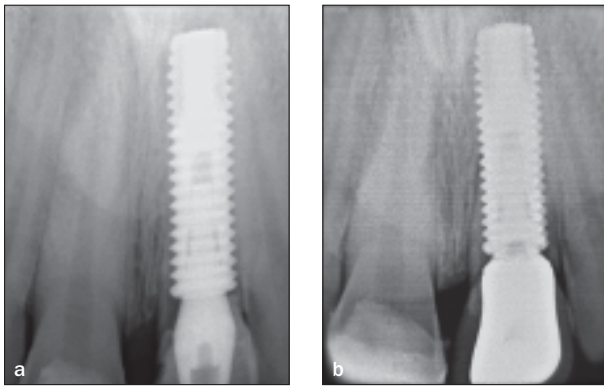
Periapical digital radiographs of the same clinical case taken immediately postloading, (a) baseline and (b) at the 4-year follow-up appointment, showing good stability of the crestal bone level. Note a shift in angle between the two radiographs, ie, the absence of distal interproximal space in (b). The implant length was utilized for digital calibration of the radiographic image to compensate for elongation of the periapical radiograph.
